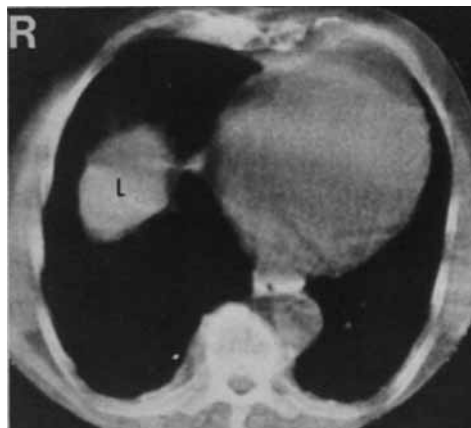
Case 1*: A CT scan cut 3cm. above the diaphragmatic level showing the intrathoracic supradiaphragmatic mass having the same attenuation coefficient as that of liver.
